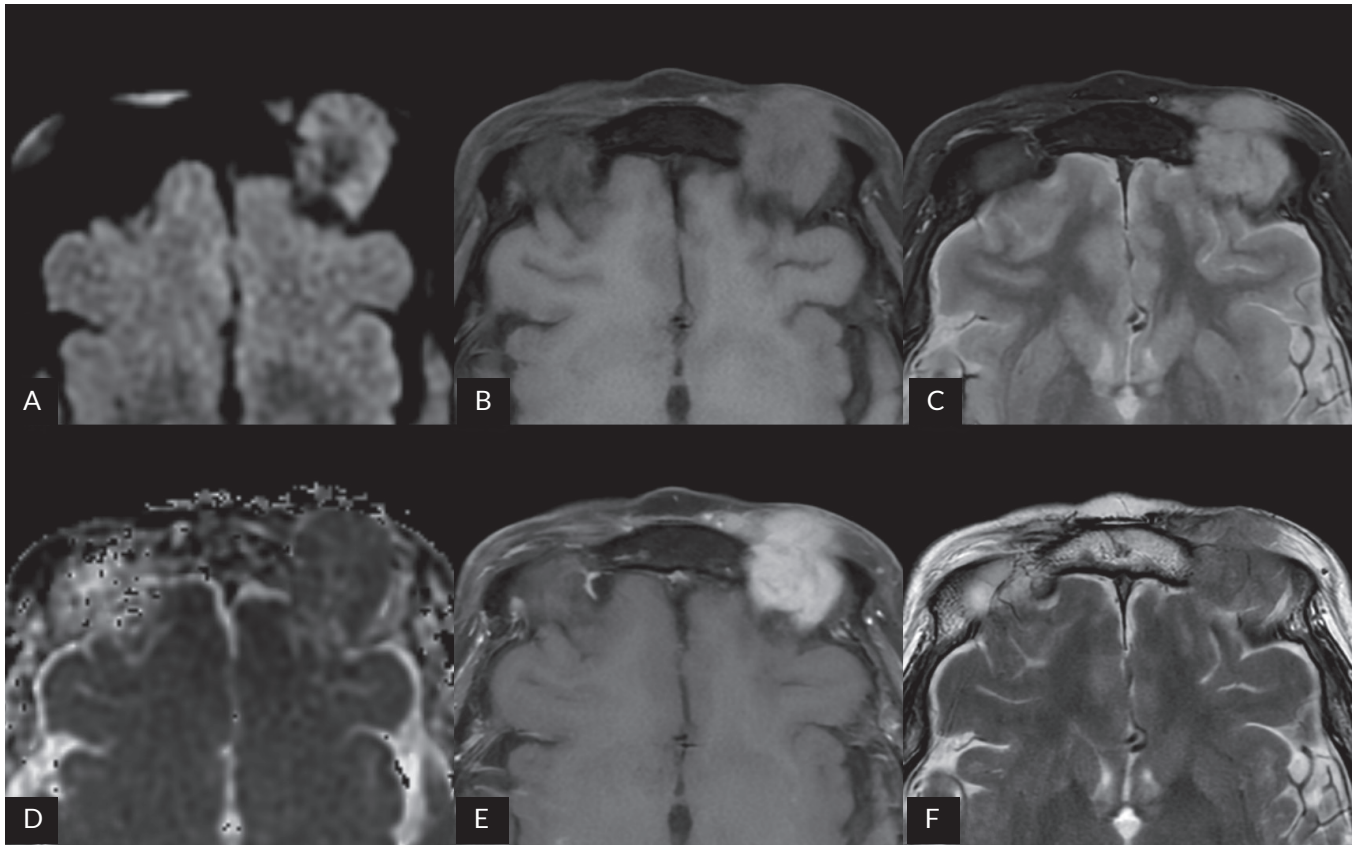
Selected transverse orbital MRI scans demonstrate a lymphoma at the left orbital roof. A. DWI image. B. Pre-contrast T1-weighted image with fat suppression. C. STIR image. D. ADC map. E. Post-contrast T1-weighted image with fat suppression. F. T2-weighted image
